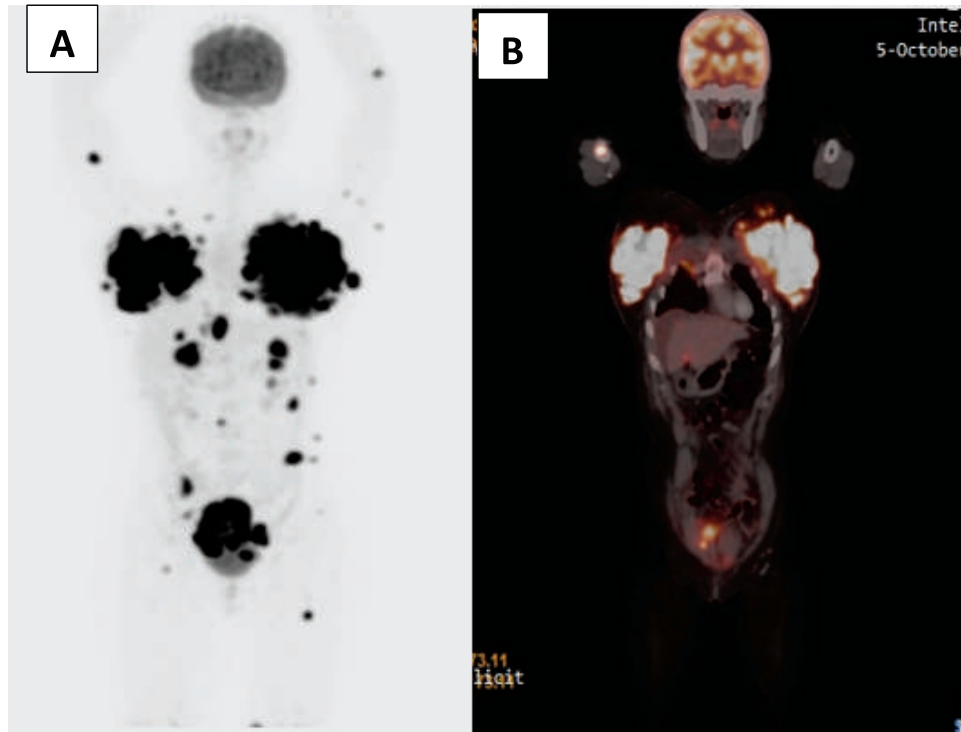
Maximum Intensity Projection (MIP) view (A) and coronal fused view (B) of ^{18}F -FDG PET-CT showed hypermetabolic masses in both breasts, along with widespread nodal and extranodal involvement.
